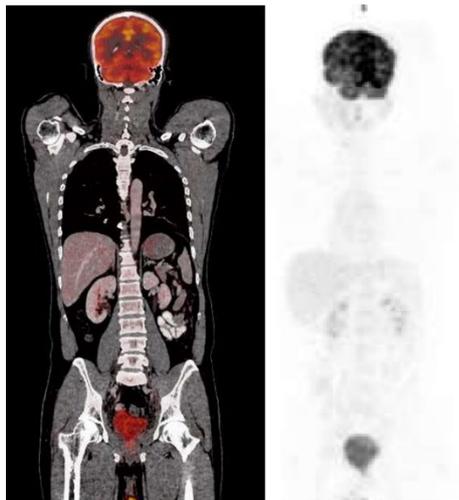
(D) & (E): Coronal (A) & (B) image showing FDG PET/CT Post radical prostatectomy. No FDG avid lesion is seen in the body.
